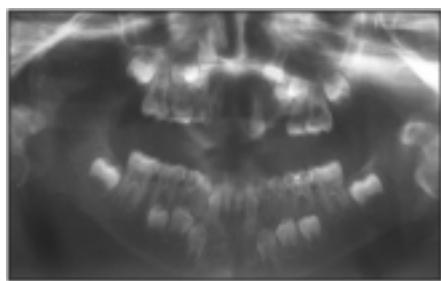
Figure II; Preoperative radiograph showing avulsed 11, 21, 63, 64 and extruded 22, 31 and 41.
